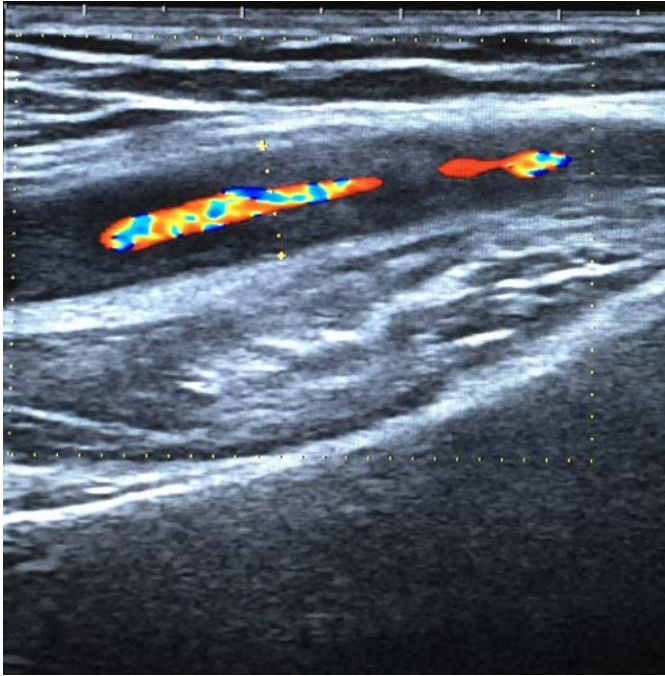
Left axillary artery ultrasound, longitudinal view, before treatment. Hypoechoic wall swelling (halo), size 1.8 mm.
